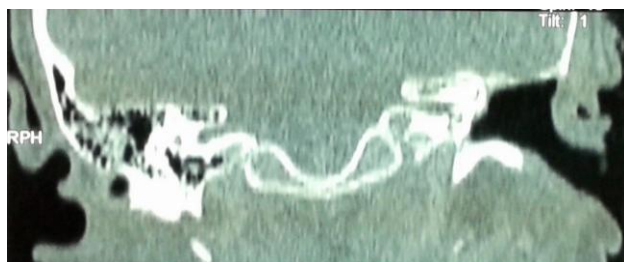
Coronal CT scan after radical tympanomastoidectomy showed normal findings.
